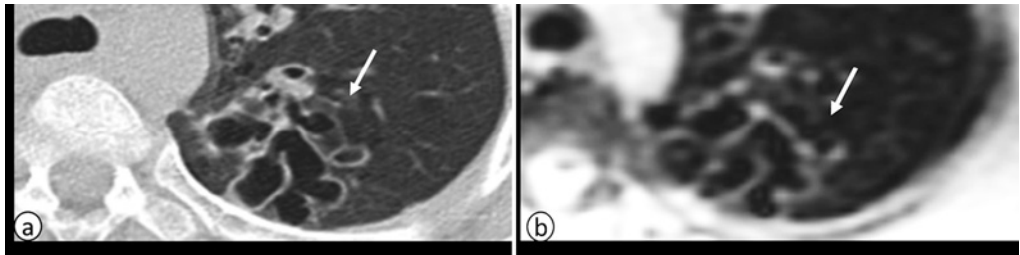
Bronchiectasis. CT (a) versus 2D SSFP MRI (b) in 14 year old cystic fibrosis boy with bronchiectasis (white arrows) in the left upper lobe.
